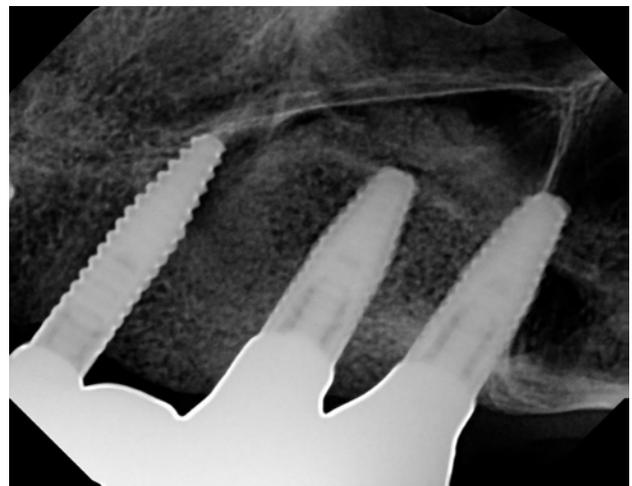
One-year postoperative periapical radiographs of the three implants.
